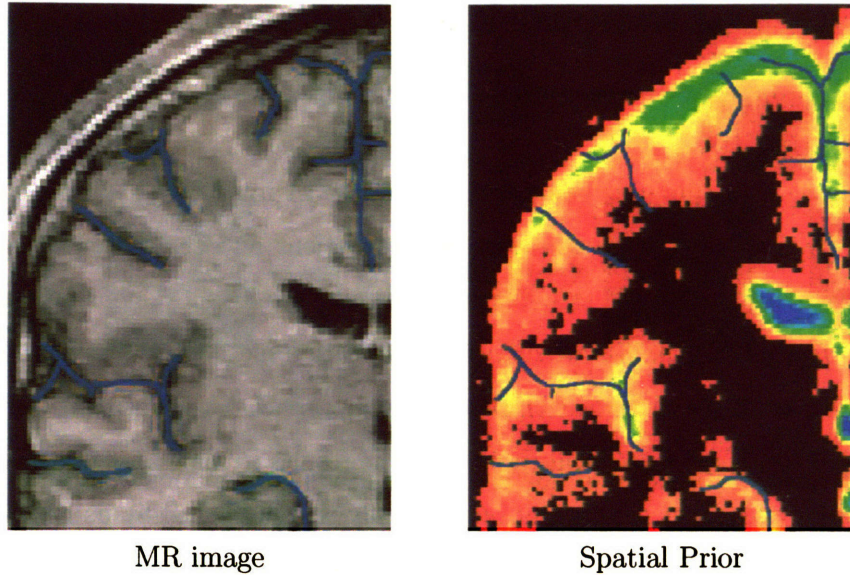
The image to the left shows a part of an MR image with blue highlighting the thin sulci filled with corticospinal fluid. Due to the great variance of the thin sulci the spatial priors under-represent the structure. This is also shown in the right image, where red indicates low spatial probability of corticospinal fluid being present.
